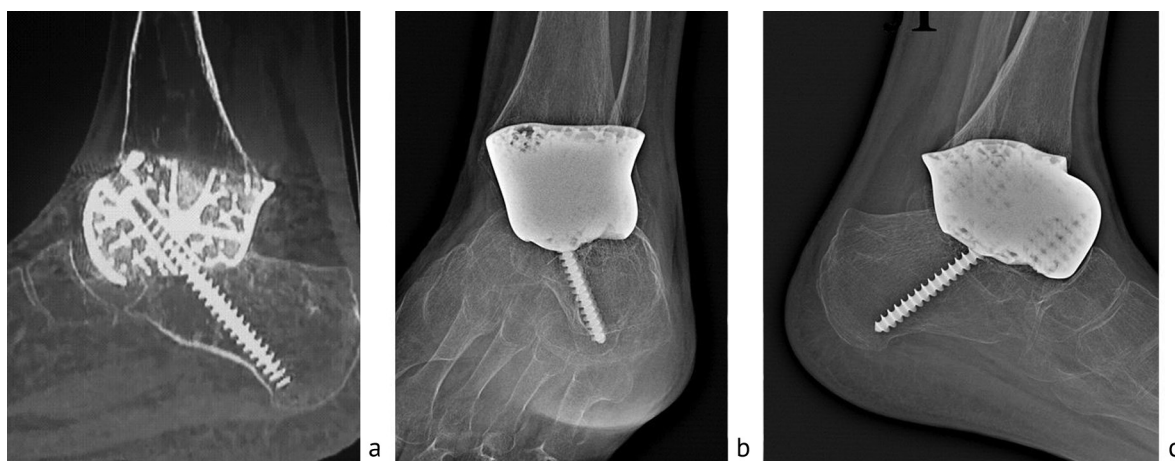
Treatment results: CT image after dismantling the Ilizarov fixator shows signs of bone remodeling (a); X-rays of the ankle joint (b) and foot (c) six months after surgery
